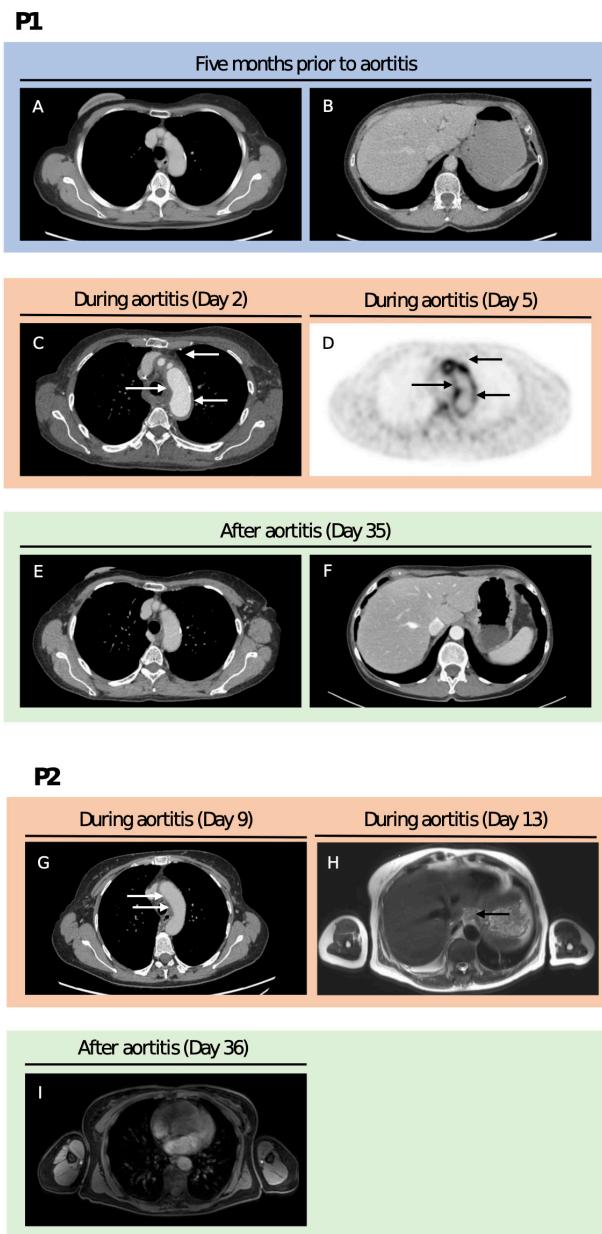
Imaging over time. This figure delineates imaging examinations over time for patient case 1 (A-F) and patient case 2 (G-I). A: Thoracic CT scan without aortic wall thickening prior to the aortitis event. B: Abdominal CT scan without aortic wall thickening prior to the aortitis event. C: Thoracic CT scan showing thickening of tunica of the aortic wall at the level of the aortic arch. D: PET-CT with FDG uptake in the aortic wall at the level of the aortic arch. E: Follow-up thoracic CT scan showing resolution of the aortic wall thickening at the level of the aortic arch. F: Follow-up abdominal CT scan without aortic wall thickening. G: Thoracic CT scan showing signs of vasculitis in the aorta. H: MRI with inflammatory changes in the perivascular region. I: Follow-up MRI showing resolution of the inflammatory findings. Arrows point to pathological findings. P1: Patient 1; P2: Patient 2.
